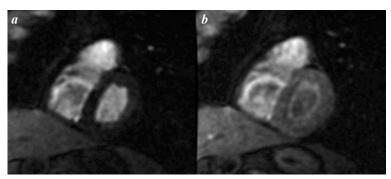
Magnetic resonance imaging with contrast at 6 months after restoration of sinus rhythm: a - contrast in the heart cavities, b - uniform distribution of contrast in the left ventricular tissues with no signs of contrast accumulation (cross-sectional view of the basal areas of the heart).
